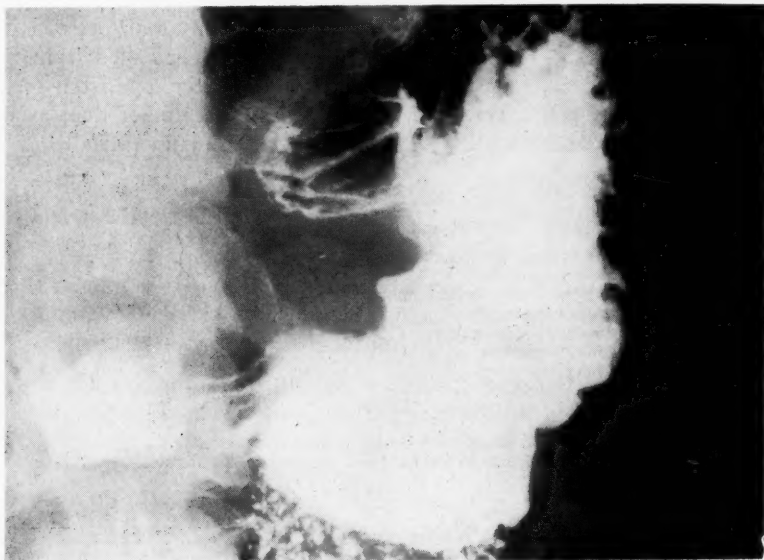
Upper gastrointestinal x-ray in case 1, showing an apparently benign gastric ulcer. Fifteen months later, an obstructing carcinoma was found at the same site.
